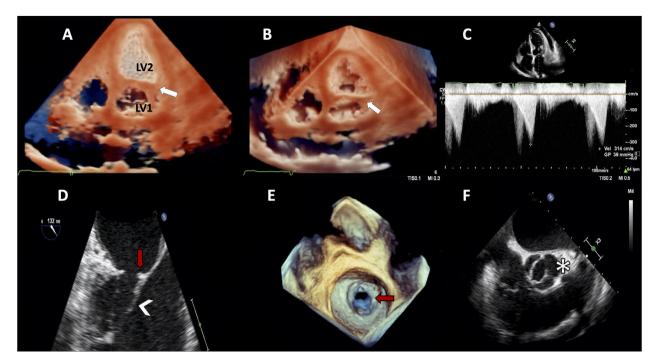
Transthoracic and transesophageal echocardiograms showing the presence of a double-chambered left ventricle; white arrow indicates the fibromuscular bundle separating the left ventricle into superior and inferior chambers (LV1 and LV2 respectively) (A-C); supravalvular mitral membrane (red arrow) (D and E); parachute mitral valve (D, arrowhead); and bicuspid aortic valve (F, asterisk).
